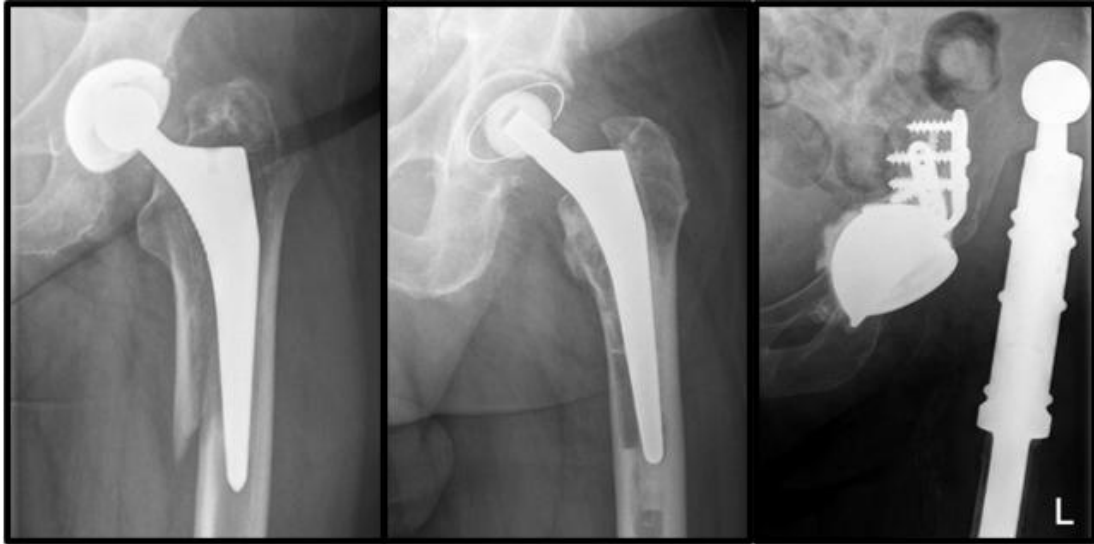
left: radiograph showing a periprosthetic fracture of the femur; middle: radiograph showing osteolytic lesions in a femur; right: radiograph showing luxation of a THA
